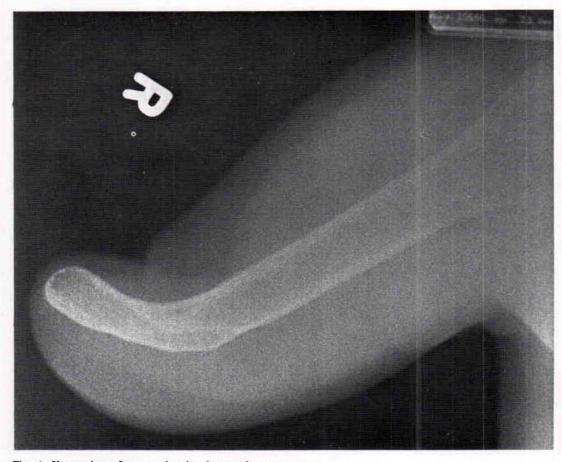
X-ray view of stump showing humeral osteotomy
